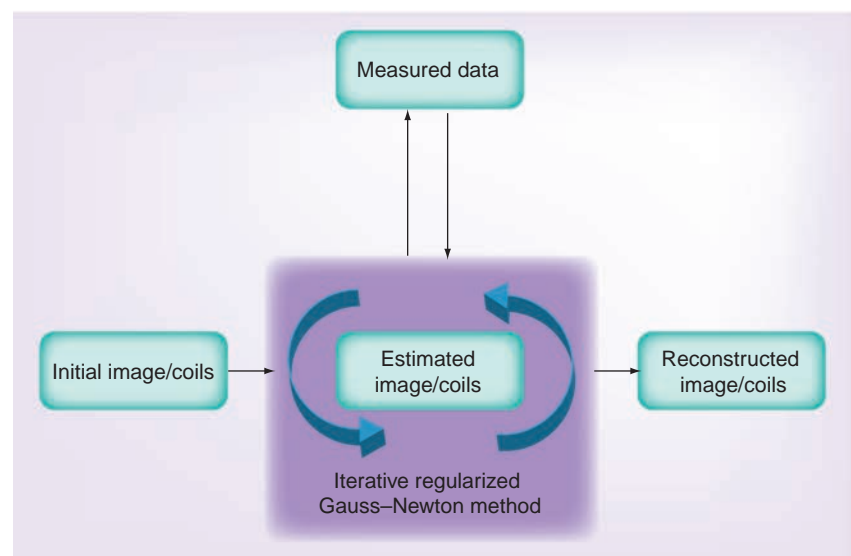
The iterative algorithm for image reconstruction of highly undersampled MRI data sets. The image and coil sensitivities for parallel MRI are defined as the solution of a nonlinear inverse problem, which is obtained by an iteratively regularized Gauss–Newton method. Starting from an initial guess, optimization of the estimated image is usually achieved within six to ten steps. In mathematical terms the badly conditioned problem may effectively be constrained by exploiting the temporal continuity of successive frames in a movie.
